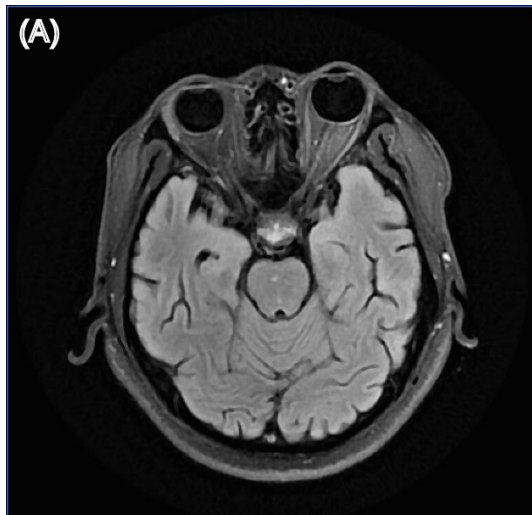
Structural brain MRI images of patient 27. (A) T2-weighted fluid-attenuated inversion recovery (T2-FLAIR) image; (B) Gadolinium-enhanced T1-weighted (Gd-T1w) image.
